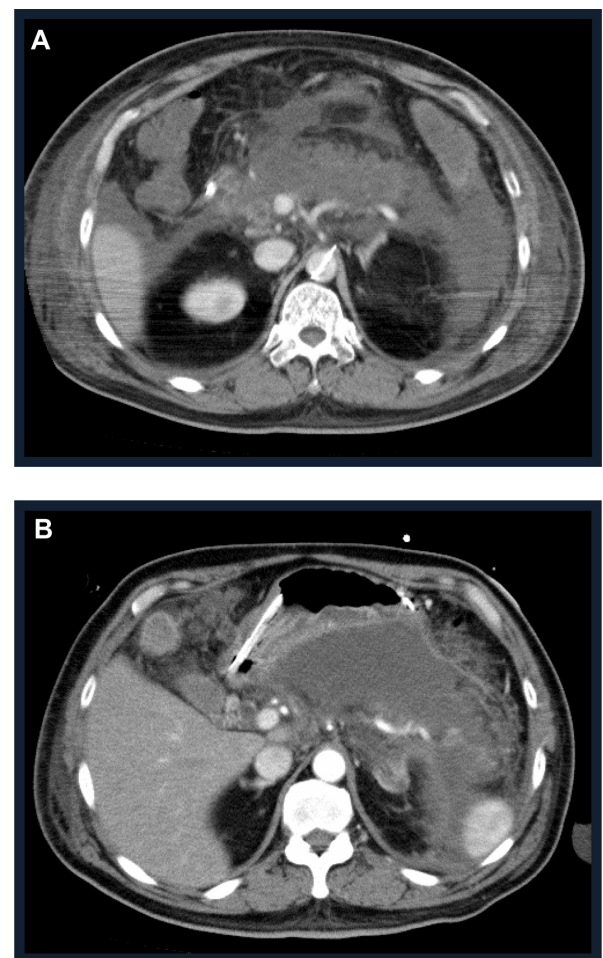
A computed tomography (CT) scan of the abdomen on admission revealed peripancreatic inflammatory changes, with ascites on liver surface, abdominopelvic cavity, peripancreatic posterior pararenal extraperitoneal space (A). A CT scan of the abdomen on 13th day after hospitalization revealed poorly enhanced areas in the body and tail of the pancreas consistent with necrosis and cyst formation (B).
